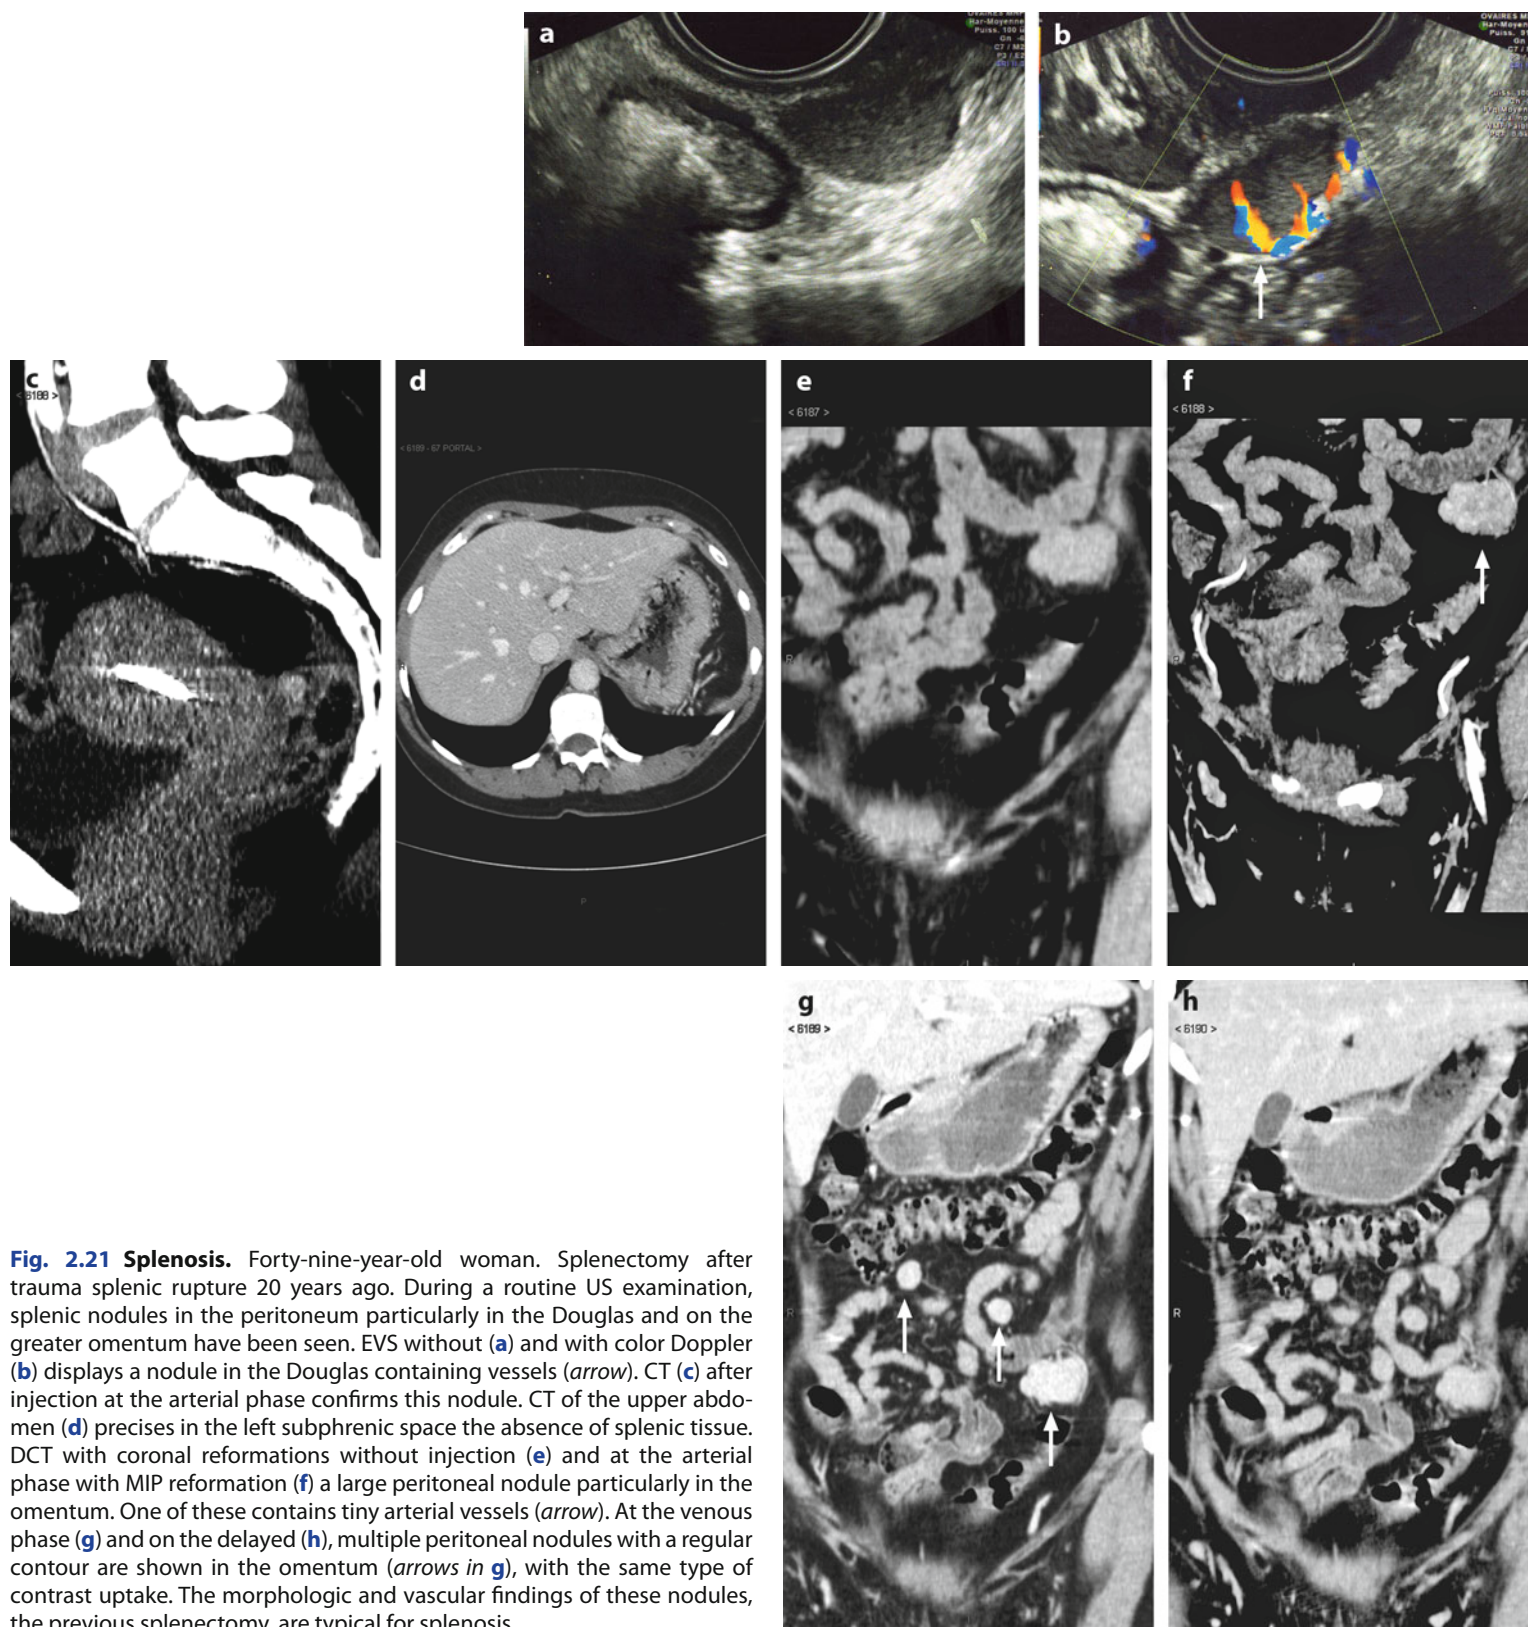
Splenosis. Forty-nine-year-old woman. Splenectomy after trauma splenic rupture 20 years ago. During a routine US examination, splenic nodules in the peritoneum particularly in the Douglas and on the greater omentum have been seen. EVS without (a) and with color Doppler (b) displays a nodule in the Douglas containing vessels (arrow). CT (c) after injection at the arterial phase confirms this nodule. CT of the upper abdomen (d) precises in the left subphrenic space the absence of splenic tissue. DCT with coronal reformations without injection (e) and at the arterial phase with MIP reformation (f) a large peritoneal nodule particularly in the omentum. One of these contains tiny arterial vessels (arrow). At the venous phase (g) and on the delayed (h), multiple peritoneal nodules with a regular contour are shown in the omentum (arrows in g), with the same type of contrast uptake. The morphologic and vascular findings of these nodules, the previous splenectomy, are typical for splenosis
